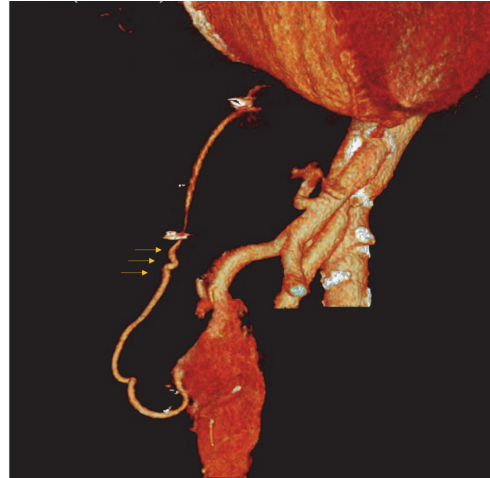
Postoperative CT angiography showing the RGEA graft. The RGEA graft had a coil-like stenosed section (yellow arrow). The RGEA was not occluded, but there was less blood flow past the stenotic area.
